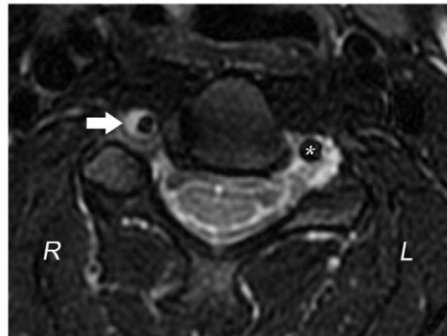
Axial gradient echo MRI demonstrates a narrowed lumen of the right vertebral artery compared to the left (asterisk) with a crescent-shaped mural thickening of high intensity (arrow) compared to the flow void within the lumen.
